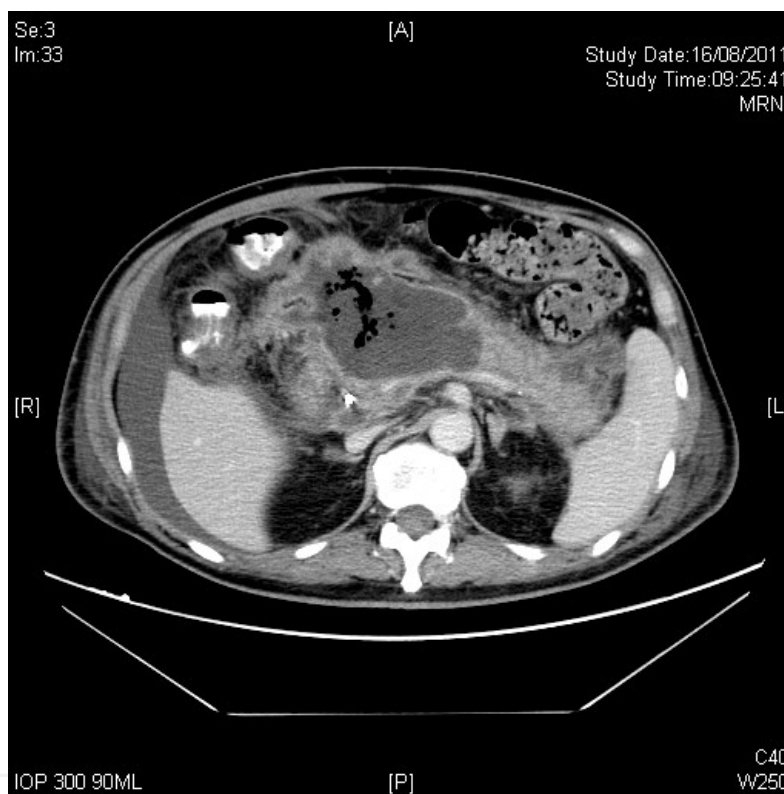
CT scan of a patient suffering from pancreatic abscess as evident by the presence of a fluid collection at the neck of the pancreas and associated air locules.
